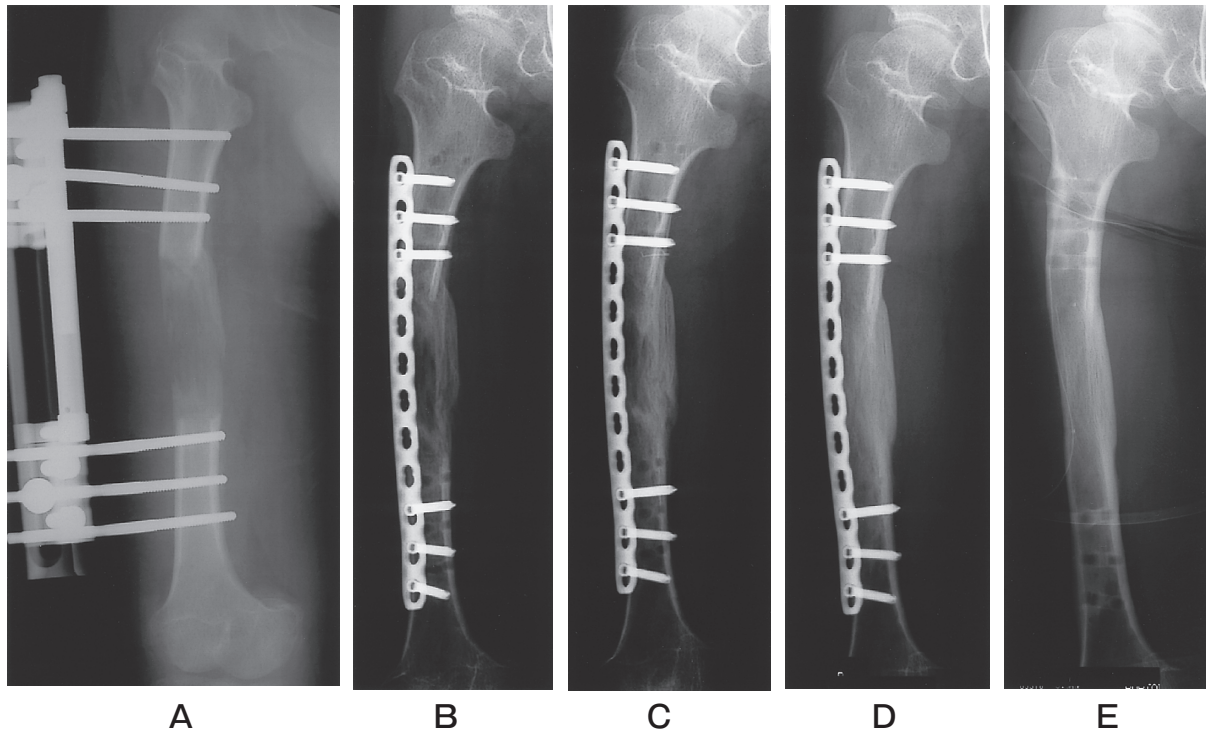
The change of the femur on the radiographs before and after plating in Case No. 1. A, 1 month before plating; B, 1 month; C, 4 months; and D, 10 months after plating; E, 19 months after plating, after implant removal.
